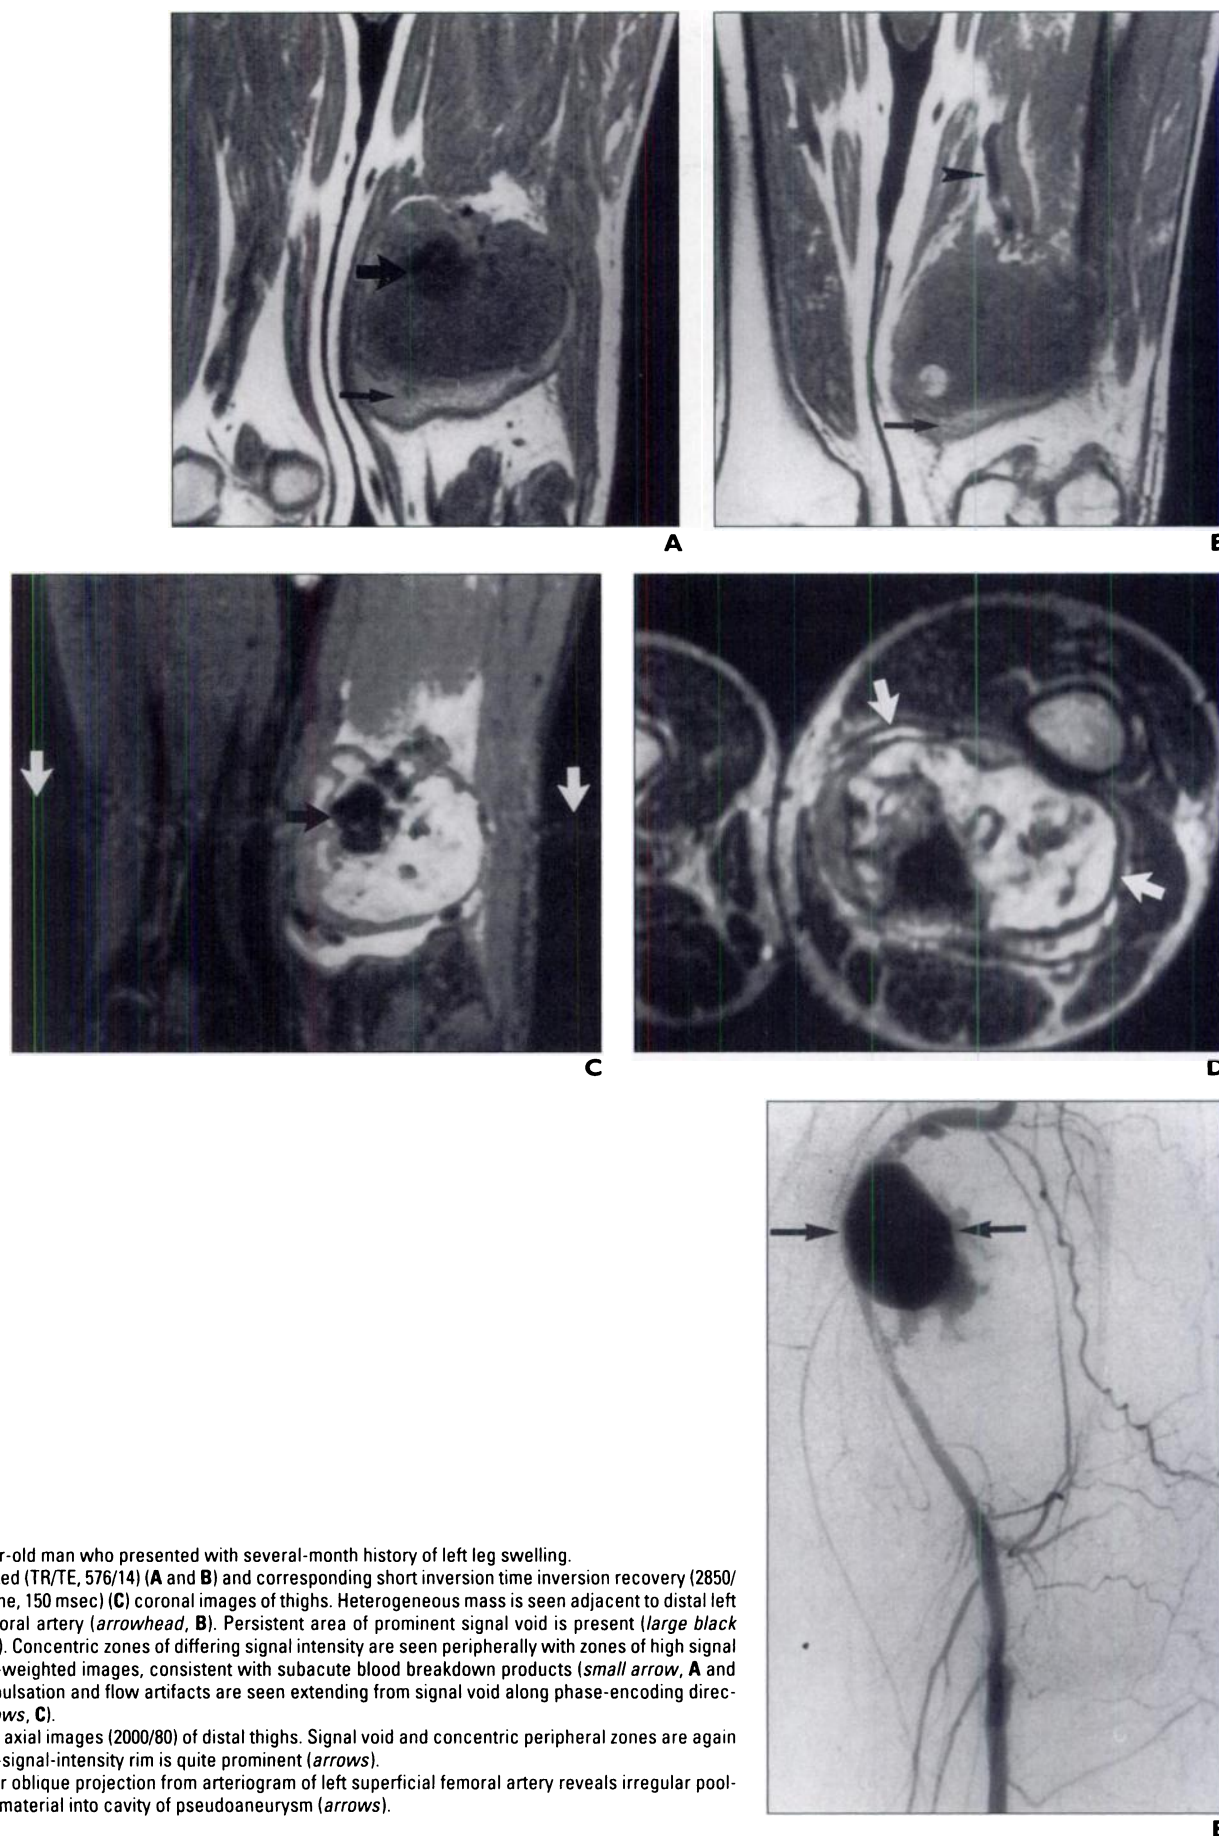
58-year-old man who presented with several-month history of left leg swelling. A–C, T1-weighted (TR/TE, 576/14) (A and B) and corresponding short inversion time inversion recovery (2850/20; inversion time, 150 msec) (C) coronal images of thighs. Heterogeneous mass is seen adjacent to distal left superficial femoral artery (arrowhead, B). Persistent area of prominent signal void is present (large black arrow, A and C). Concentric zones of differing signal intensity are seen peripherally with zones of high signal intensity on T1-weighted images, consistent with subacute blood breakdown products (small arrow, A and B). Prominent pulsation and flow artifacts are seen extending from signal void along phase-encoding direction (white arrows, C). D, T2-weighted axial images (2000/80) of distal thighs. Signal void and concentric peripheral zones are again identified. Low-signal-intensity rim is quite prominent (arrows). E, Right anterior oblique projection from arteriogram of left superficial femoral artery reveals irregular pooling of contrast material into cavity of pseudoaneurysm (arrows).
